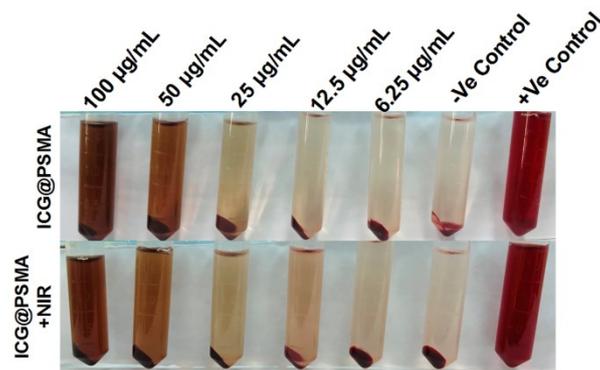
The hemolytic effect of ICG@PSMA NPs in all formulations at different concentrations (6.25, 12.5, 25, 50, and $100 \mu\text{g/mL}$)
